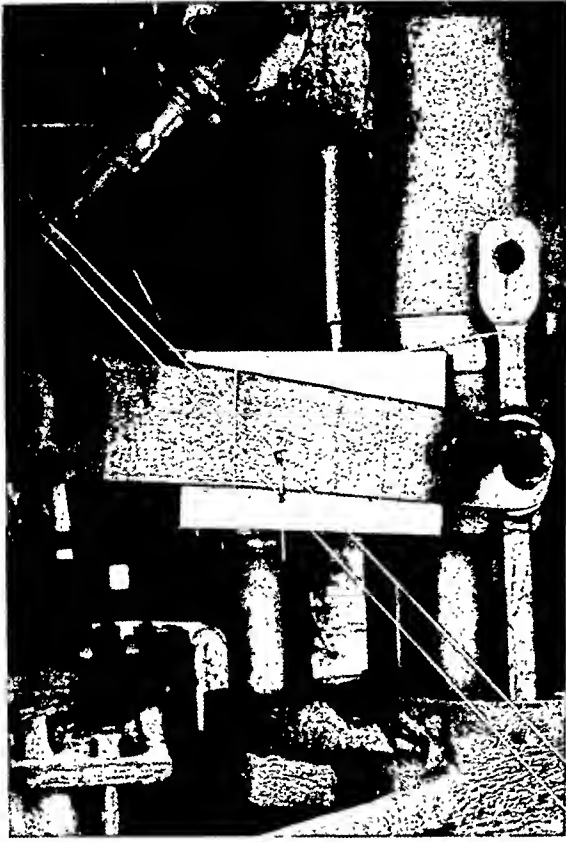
Glass funnel, supported by strings, holds radium in front of an arm of a forge press for radiographic inspection *in situ*.
